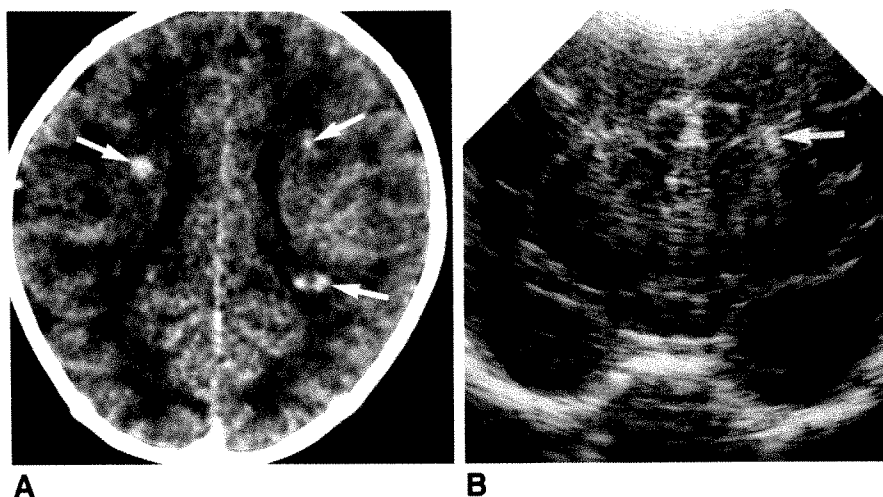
Small periventricular hemorrhages not seen on sonography.
